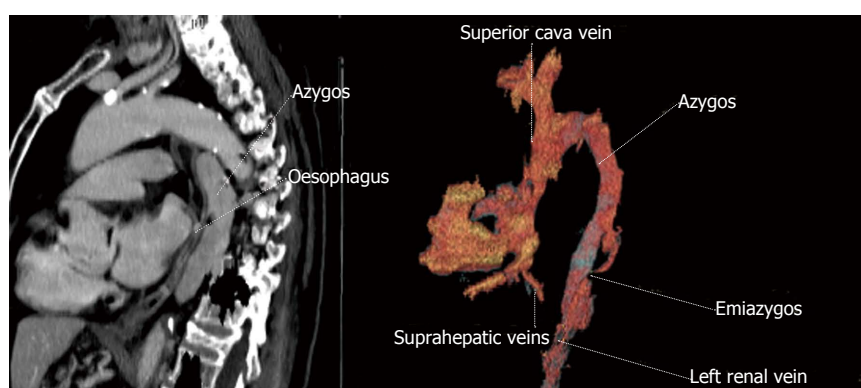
Computed tomography view of a dilated ascending thoracic aorta with no presence of the inferior vena cava with azygos continuation, cause of the vascular compression of esophagus.
